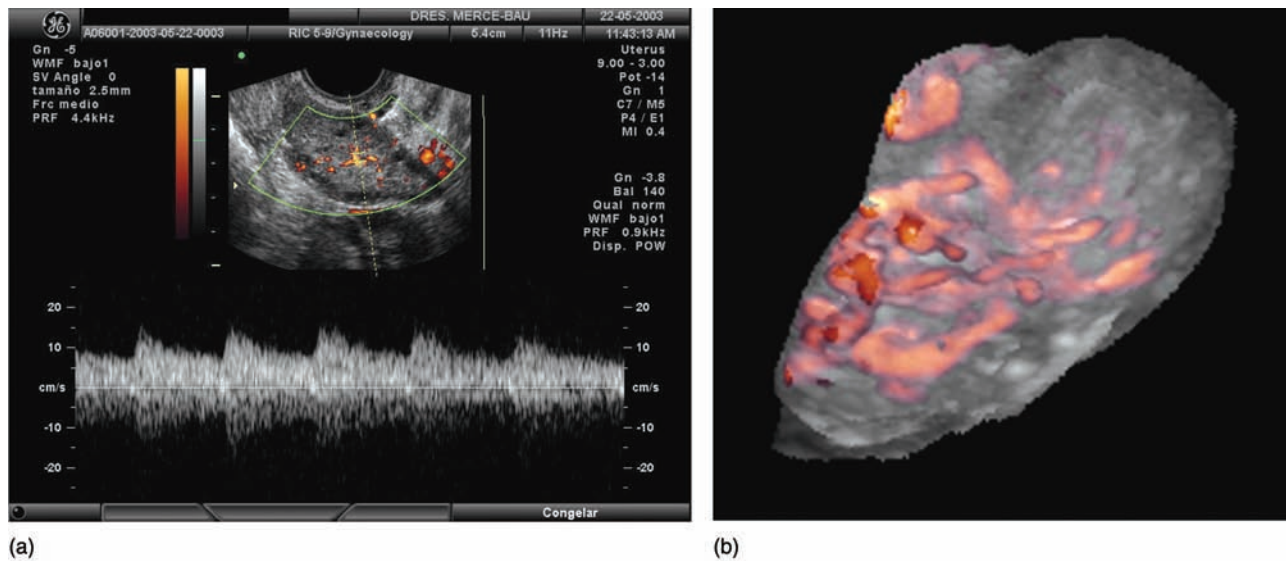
Sonographic markers of the ovarian response. (a) Recording of the ovarian stromal flow velocity wave (FWV) after pituitary suppression by GnRh analogs. The peak systolic velocity is a good predictor of the number of follicles to grow. (b) Three-dimensional ultrasonography and power Doppler angiography allow the assessment of all the sonographic and Doppler parameters involved in the prediction of the ovarian response.
